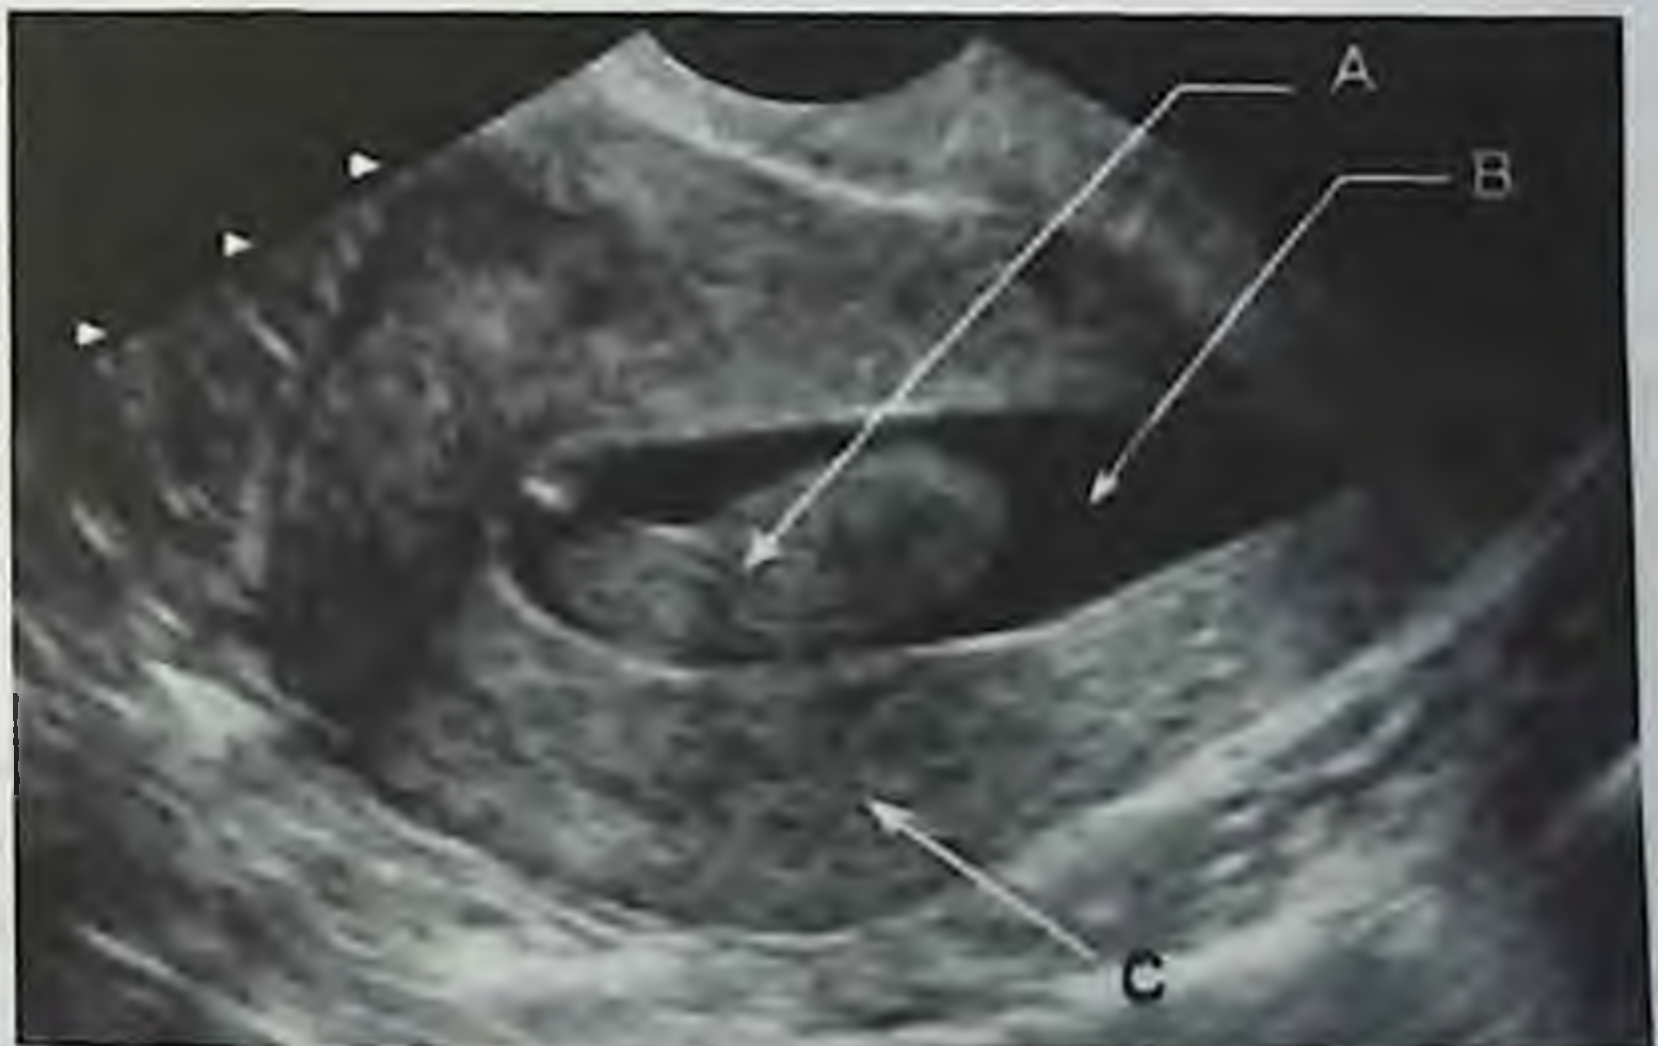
Ultrasound picture of the endometrial polyp*
